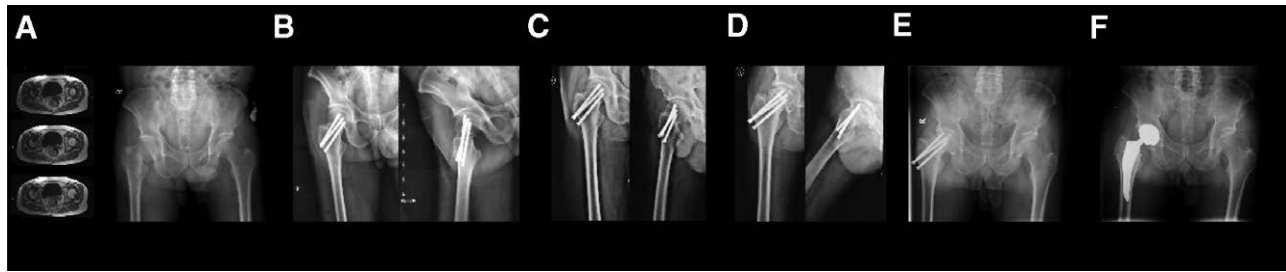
A patient who had internal fixation finally turned to total hip arthroplasty because of the progression of the femoral head necrosis. (A) A 58-year-old male patient was diagnosed with right femoral head necrosis. Three months after the initial diagnosis of osteonecrosis, the patient experienced a right femoral neck fracture due to a fall. (B) The radiograph immediately after the surgery showed that the patient underwent close reduction and internal fixation with 3 screws. (C) Six months after the internal fixation surgery, the radiograph showed that the fracture was union. (D) Two years after the internal fixation surgery, the radiograph showed right femoral head necrosis progression. Compared with the radiograph immediately after the surgery, a significant collapse of the patient's right femoral head was identified. (E) Three years after the internal fixation surgery, the patient's right femoral head collapse continuously progressed, affecting his daily life. (F) The patient ultimately underwent a right 2-stage hip arthroplasty.
